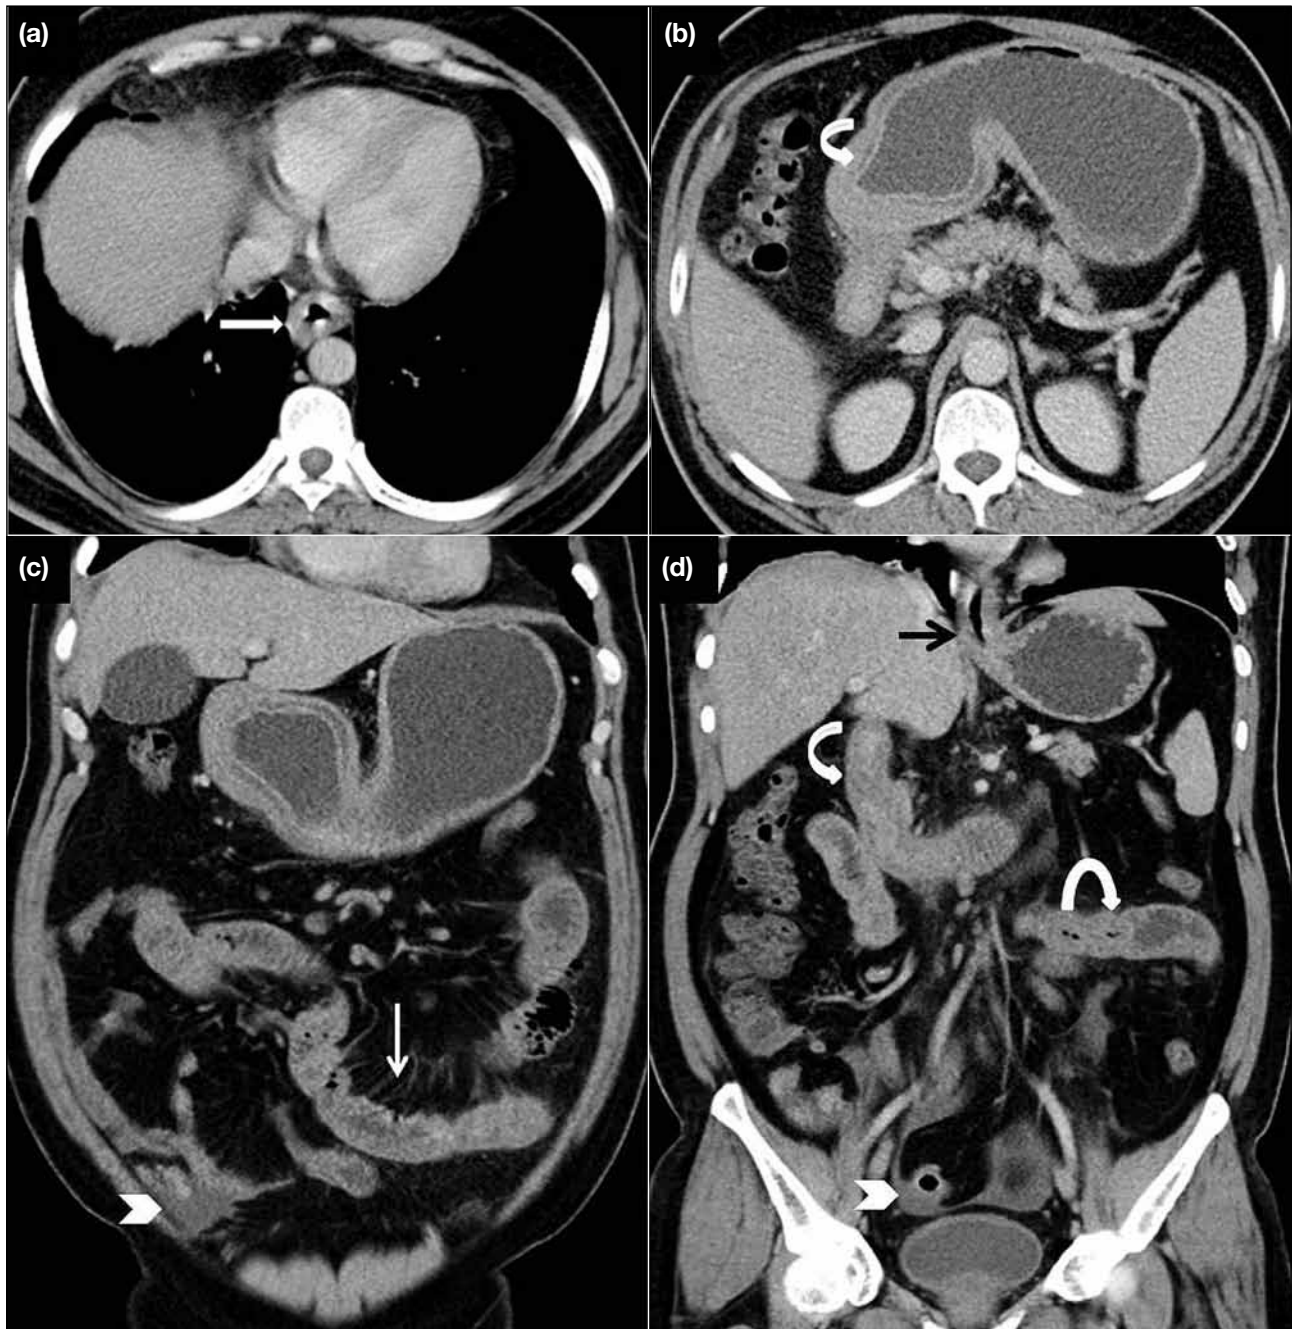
(a and b) Contrast-enhanced axial computed tomography images showing wall thickening of the lower dorsal oesophagus (straight arrow), with layered wall thickening of the antrum and a hypodense halo within (curved arrow). (c and d) Contrast-enhanced coronal computed tomography images showing markedly increased mesenteric vascularity (straight white arrow) with wall thickening of the duodenum, proximal jejunal loops (curved arrows), lower oesophagus (straight black arrow), and gastric antrum. A small amount of free fluid can be seen in the lower abdomen and pelvis (chevrons).
